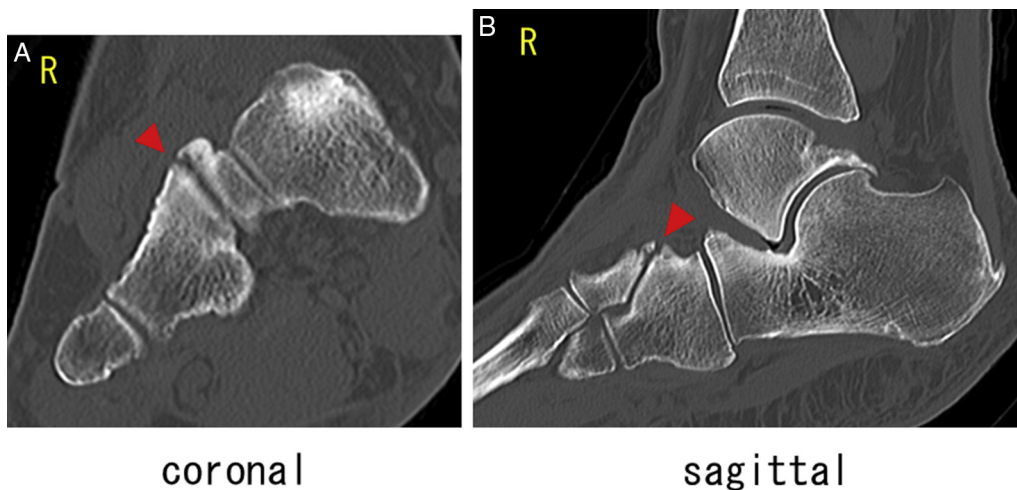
(A to C) A 60-year-old female presented with a nonosseous tarsal coalition of the lateral cuneocuboid joint. On the plain radiographs, no clear abnormalities were seen on the dorsoplantar image; however, the oblique view showed an irregularity in the articular surface of the lateral cuneocuboid joint (C, arrowhead).
